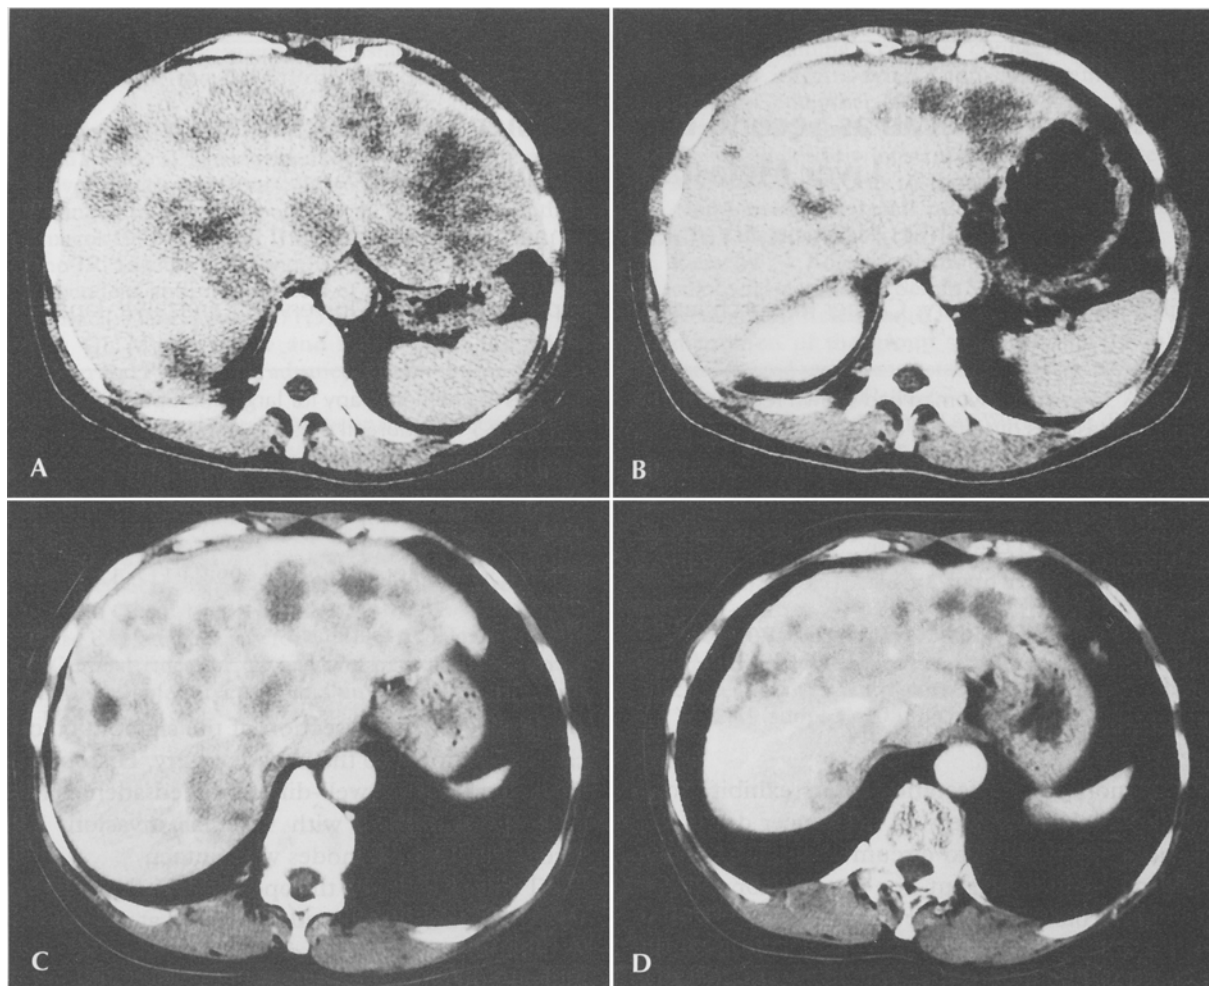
Abdominal CT scans of a 53-year-old woman showing liver metastases of sigmoid colon cancer, (A) before and (B) after a 4-month treatment with 5-fluorouracil plus leucovorin, and (C) just before and (D) after 2 cycles of treatment with CPT-11 (irinotecan).
